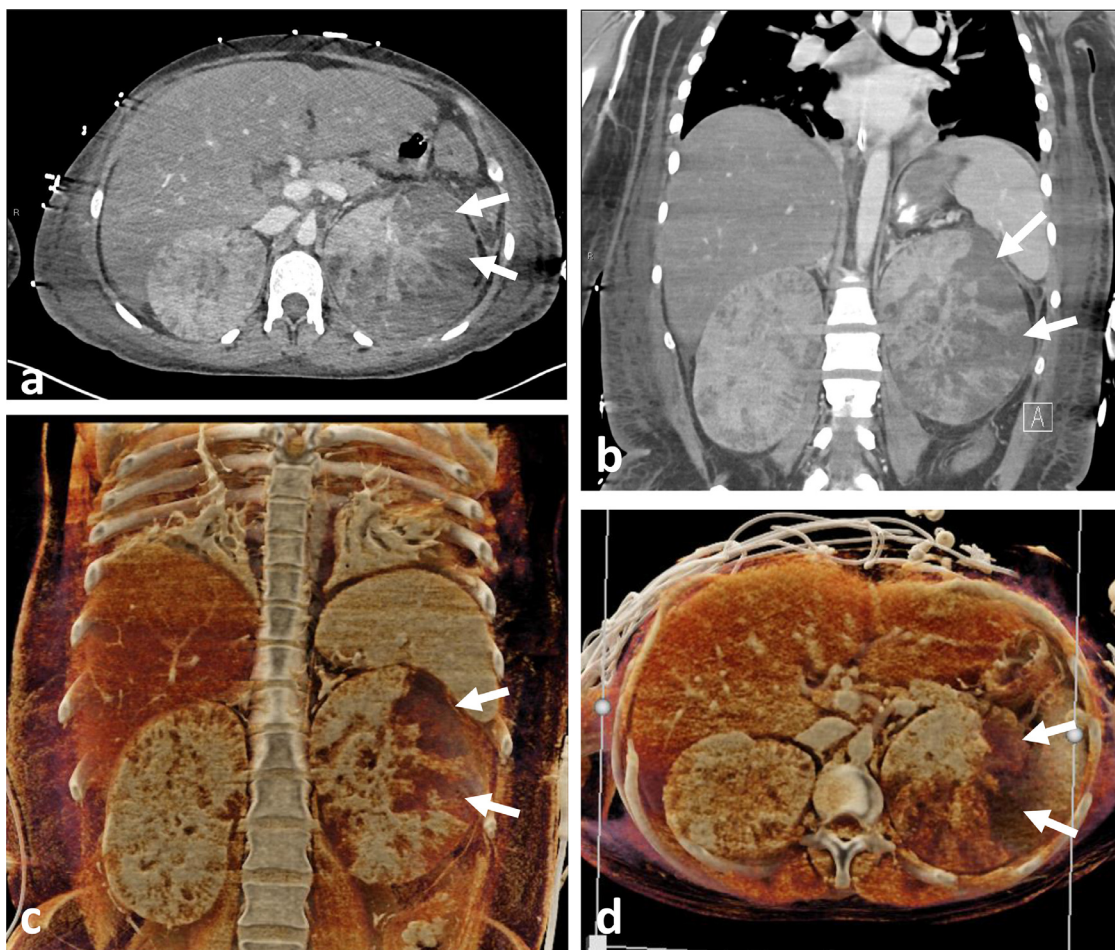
Axial (a) and coronal (b) venous phase CT scan at the level of the kidneys demonstrating bilateral nephromegaly with poor corticomedullary differentiation and multifocal hypoattenuation, most pronounced in the left kidney. Confluent regions of parenchymal hypoattenuation (arrows) may reflect abscesses and/or infarcted tissue. Coronal (c) and axial (d) cinematic renderings which further define the extent of multifocal renal abscesses (arrows) by highlighting textural differences in the renal parenchyma.
